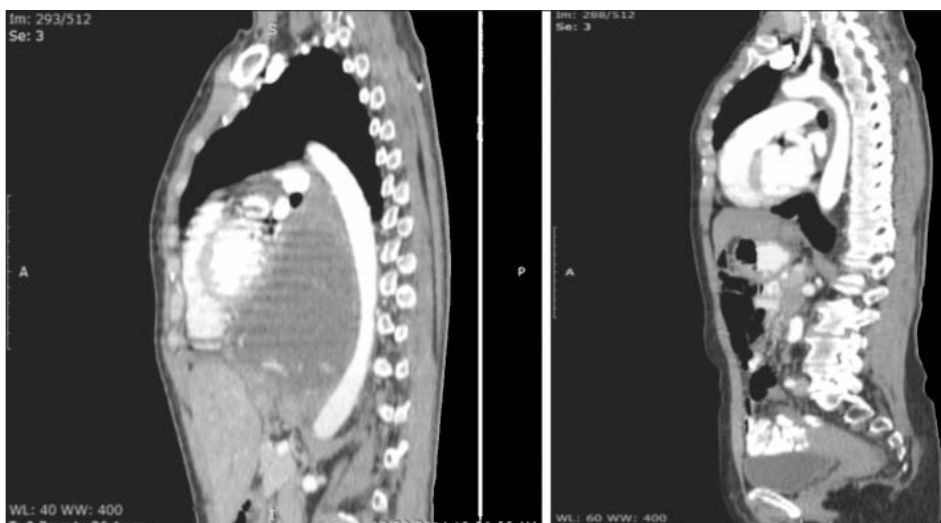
CT scan: preoperative (left) vs 5 postoperative months (right) – sagittal aspect
